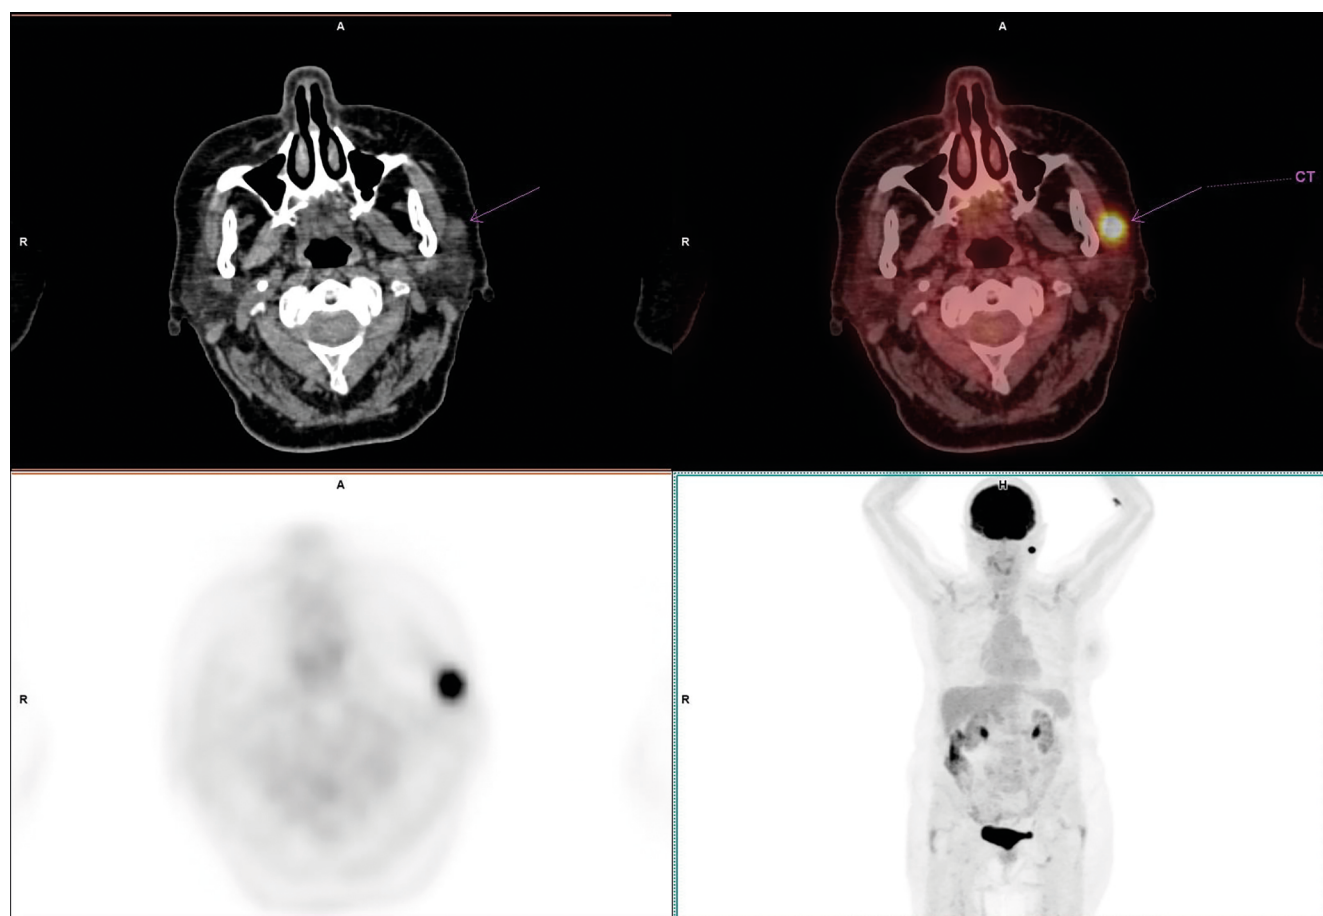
Axial CT and fused [¹⁸F]FDG PET/CT images (upper row), axial and coronal [¹⁸F]FDG PET/CT whole-body maximum intensity projection images (lower row). The metabolically active lesion in the left parotid gland was detected in [¹⁸F]FDG PET/CT. Further biopsy of the parotid gland showed a benign neoplastic process; hence, the [¹⁸F]FDG PET/CT result was qualified as false positive. The [¹⁸F]FDG PET/CT examination was performed due to clinical symptoms
